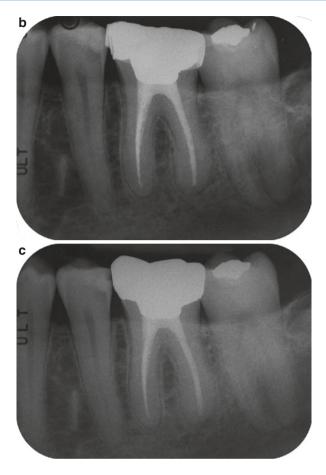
(a) Preoperative radiograph of tooth 46 with fractured rotary NiTi instrument in the mesiolingual canal. The referring practitioner attempted to remove the fragment. (b, c) The instrument was able to be bypassed via the mesiobuccal canal which merged with the mesiolingual. While structural prognosis is very compromised, endodontic prognosis is favorable (Courtesy Dr. M. Weis)
